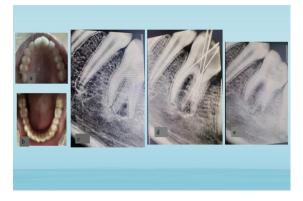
Radiographic and clinical photograph of case 2.
